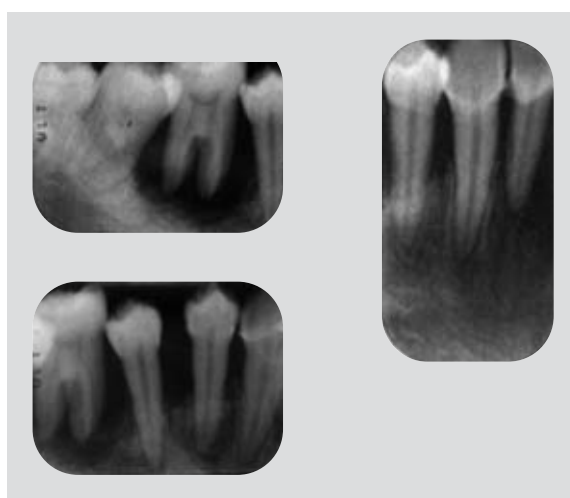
Periapical radiographs of the mandibular right quadrant at time of initial examination.
